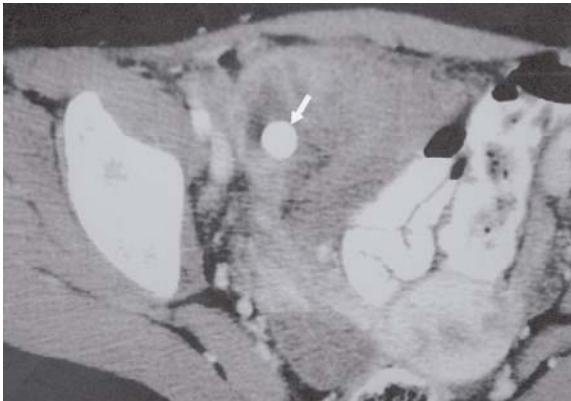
Enhanced axial CT image shows a dense appendicolith in a patient with perforated appendicitis (arrow). There is a periappendiceal inflammatory mass.
